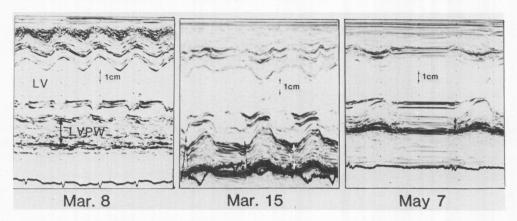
M-mode left ventricular echocardiograms.
